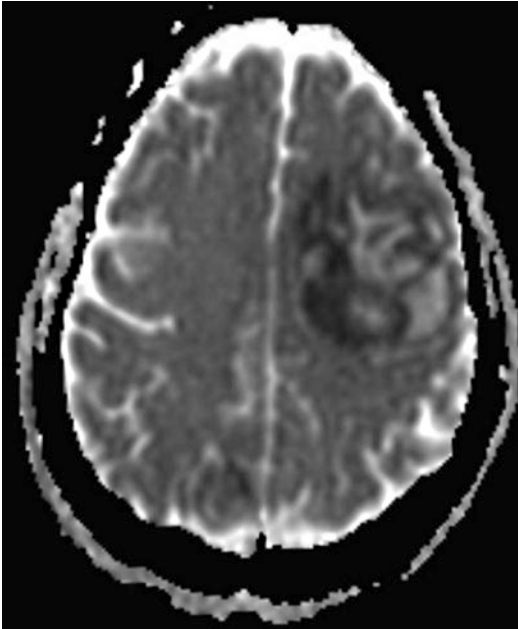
Head CT. A CT of the head reveals a mass lesion concerning for spread of her fungal infection
